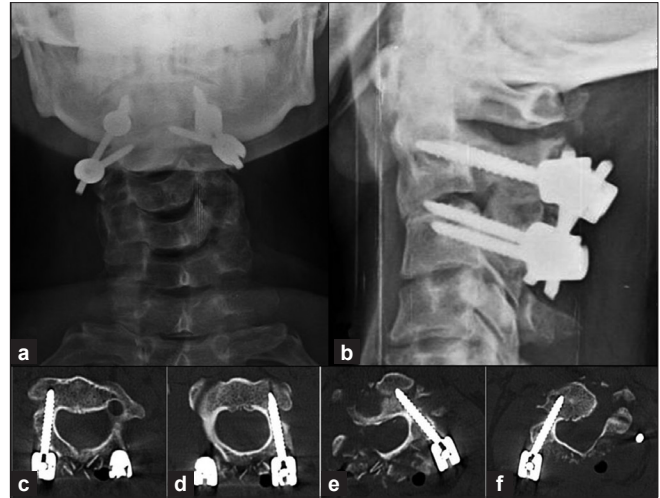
(a) Postoperative anteroposterior and (b) lateral radiographs of the cervical spine. (c and d) Postoperative axial sections of CT scan showing the accurate screw placement in the pedicles of C2 and (e and f) C3 vertebrae with the aid of Iso-C navigation
